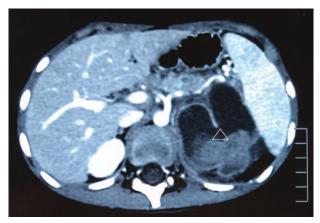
CECT reveals a large retroperitoneal cystic lesion of 61 × 90 mm in size (triangle). CECT=contrast-enhanced computed tomography.
